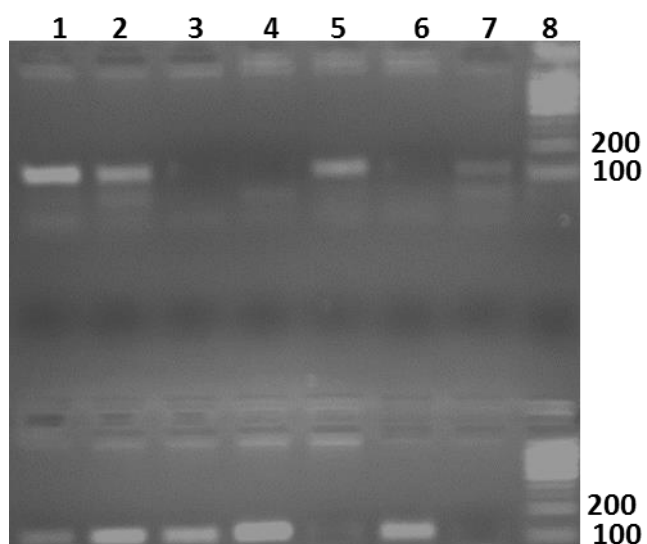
Allele specific PCR rs7903146, above row from right to the left:(1)Normal CC, (2,3),homo-mutated sample TT, (4,5)normal sample CC ,(6,7)sample with mutated and normal bands hetero-mutated CT.
